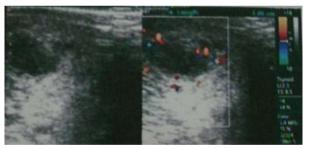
Ultrasonic image note the hypoechoic lesion with surrounding edema and hyperemia.
